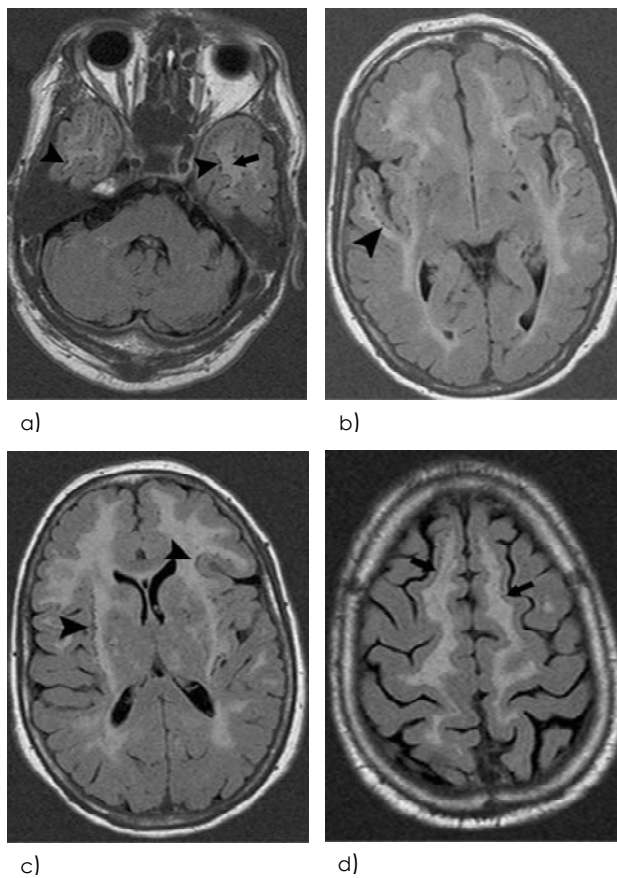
Axial FLAIR MR images in four CADASIL patients at the level of (a) the pons, (b) the operculum of the temporal lobe, (c) the basal ganglia, and (d) the high convexity. Images show bilateral SLLs affecting a) the anterior part and (b) the operculum of the temporal lobe (arrowheads) at the junction of grey and white matter. The lesions are abutting WMHs (arrow in a). From this location, lesions could expand to (c) the subinsular region and operculum of the frontal lobe (arrowheads). (d) In one patient with extensive white matter lesions, subcortical lacunar lesions were visible throughout the whole frontal lobe (arrows).
